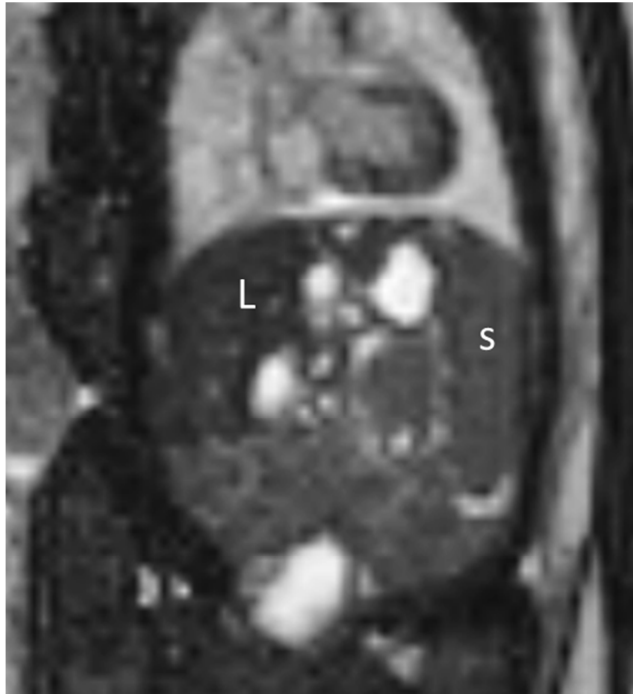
Zoom of T2-weighted axial MR imaging on fetal abdomen - hypointense atrophic liver (L) and a splenomegaly (S)
